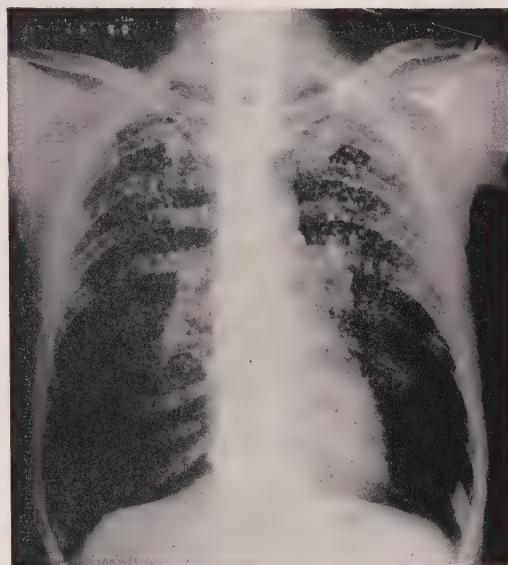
Silicosis. Roentgenogram of lungs showing distribution and relative density of lesions.
